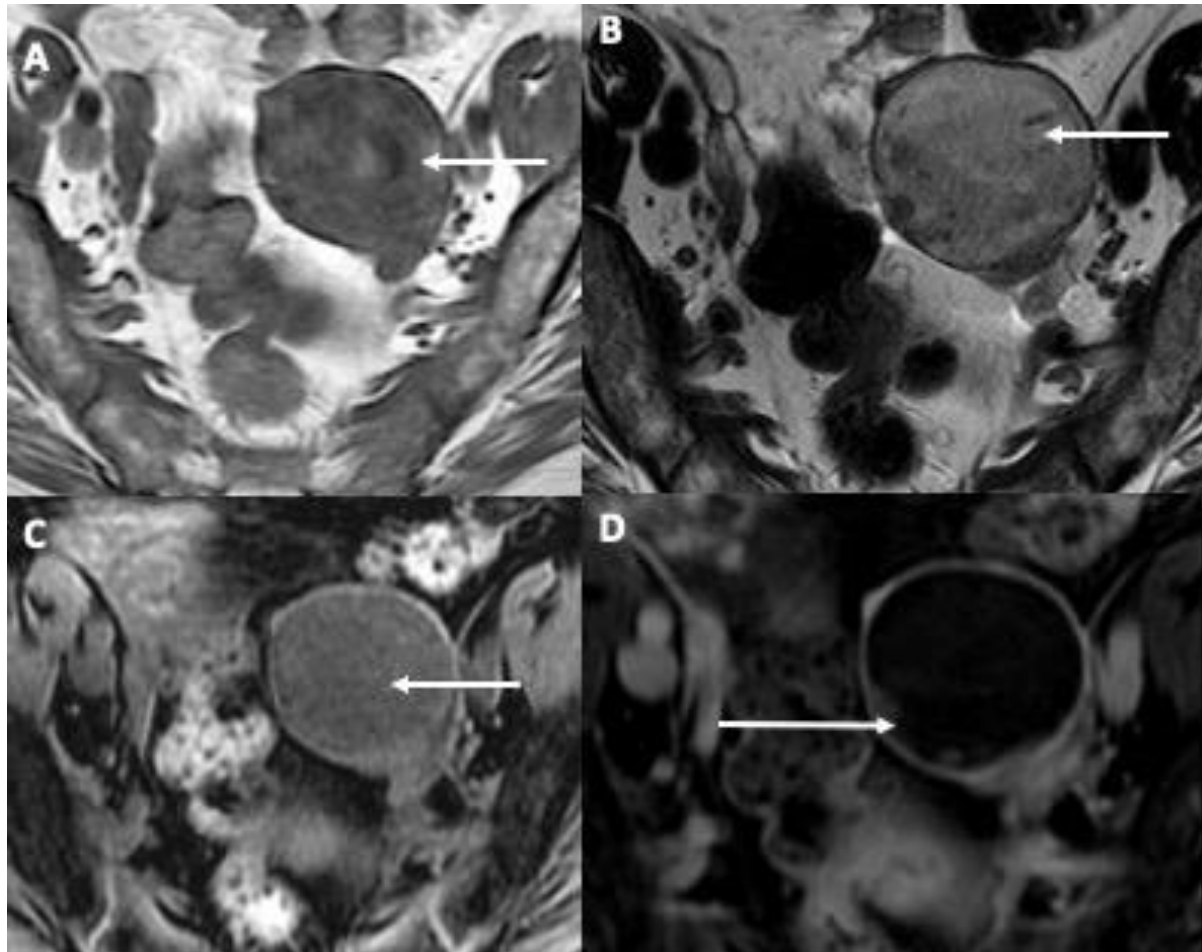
MRI of a squamous cell carcinoma arising from an MCT. MRI shows a left ovarian unilocular cystic lesion with heterogenous component (long arrows) on T1 (A), T2 (B), and T1 without contrast (C) that has loss of signal on T1-fat saturated post-contrast (D) suggestive of fat component. In addition, on T1-fat saturated after contrast (D), enhancing nodular areas on the wall are delineated as suggestive of malignant degeneration (long arrow)
